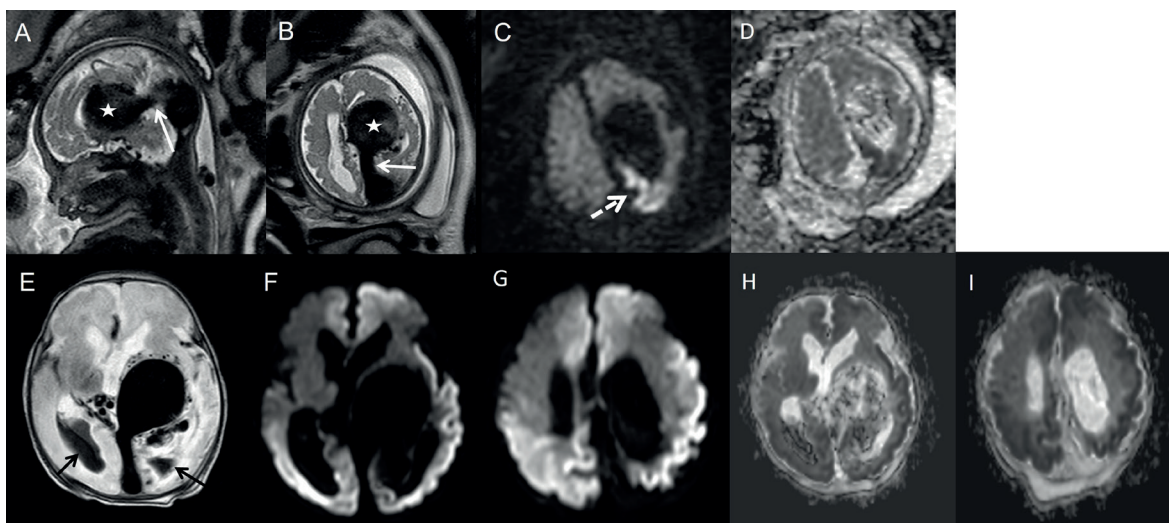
Cranial MRI studies of the patient performed in-utero (A-D) and following endovascular treatment at 7 days of age (E-I). Enormously enlarged Torcula and median prosencephalic vein (arrow) ending in a venous aneurysm (asterix) are displayed on sagittal (A) and axial (B) T2-weighted images. Restricted diffusion on average diffusion-weighted image (C) and corresponding low signal on ADC map (D) suggestive of cytotoxic edema due to acute ischemia of the left medial parietal cortex (dashed arrow) is observed. Following endovascular treatment, there is an intraventricular hemorrhage layering in the occipital horns of the lateral ventricles (black arrows) and accompanying hydrocephalus are shown on axial T2-weighted image (E) as well as bilateral extensive hemispheric cortical diffusion restriction (F-I) on both average diffusion-weighted image and ADC maps this time.
